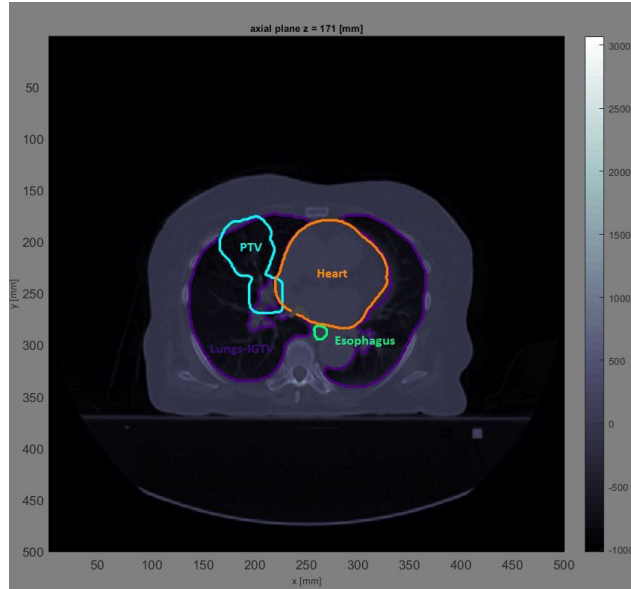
CT slice of the lung patient scan with contours for structures of interest.
